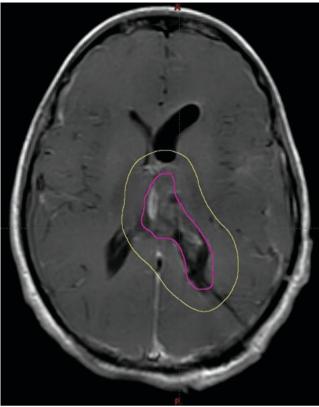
Delineation of the treatment volumes on diagnostic post-op MRI: CTV (pink) and PTV (yellow)
